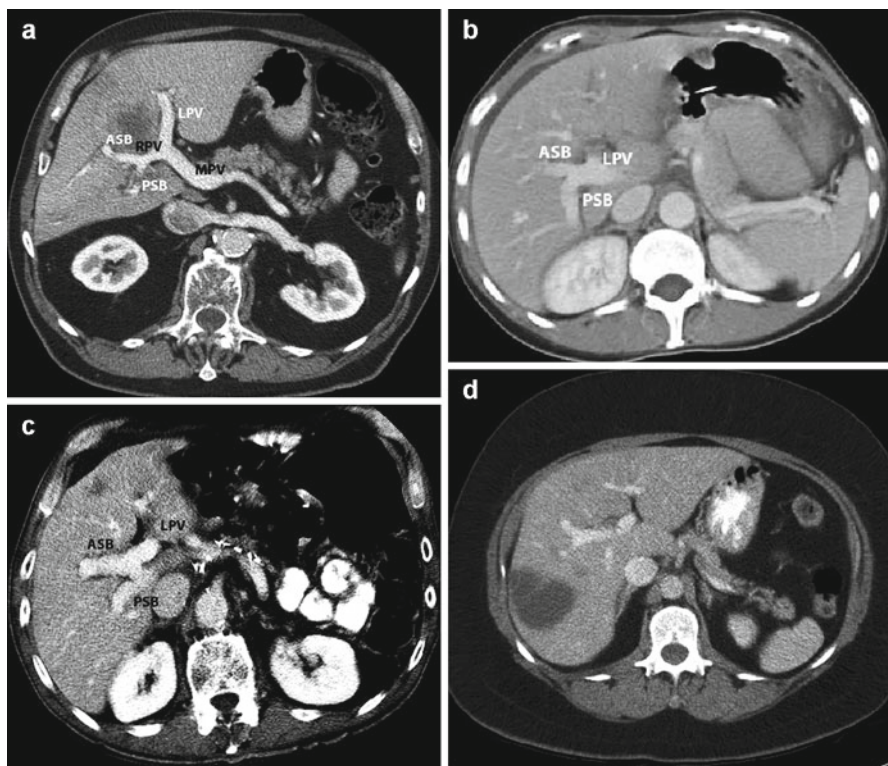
(a) CT scan showing normal portal venous anatomy with the left portal vein (*LPV*) and right portal vein (*RPV*) arising from the main portal vein (*MPV*). The *RPV* divides into an anterior sectorial branch (*ASB*) supplying segments 5 and 8 and posterior sectorial branch (*PSB*) supplying segments 6 and 7. (b) CT scan showing trifurcation of the main portal vein into *LPV*, *ASB*, and *PSB*. (c) CT scan showing early takeoff of the *PSB* from the *MPV* with subsequent division of the remaining branch into *LPV* and *ASB*. (d) CT scan showing segment-6 (*SEG 6*) branch arising from the *ASB* while the segment-7 (*SEG 7*) portal branch arises from the *MPV*
